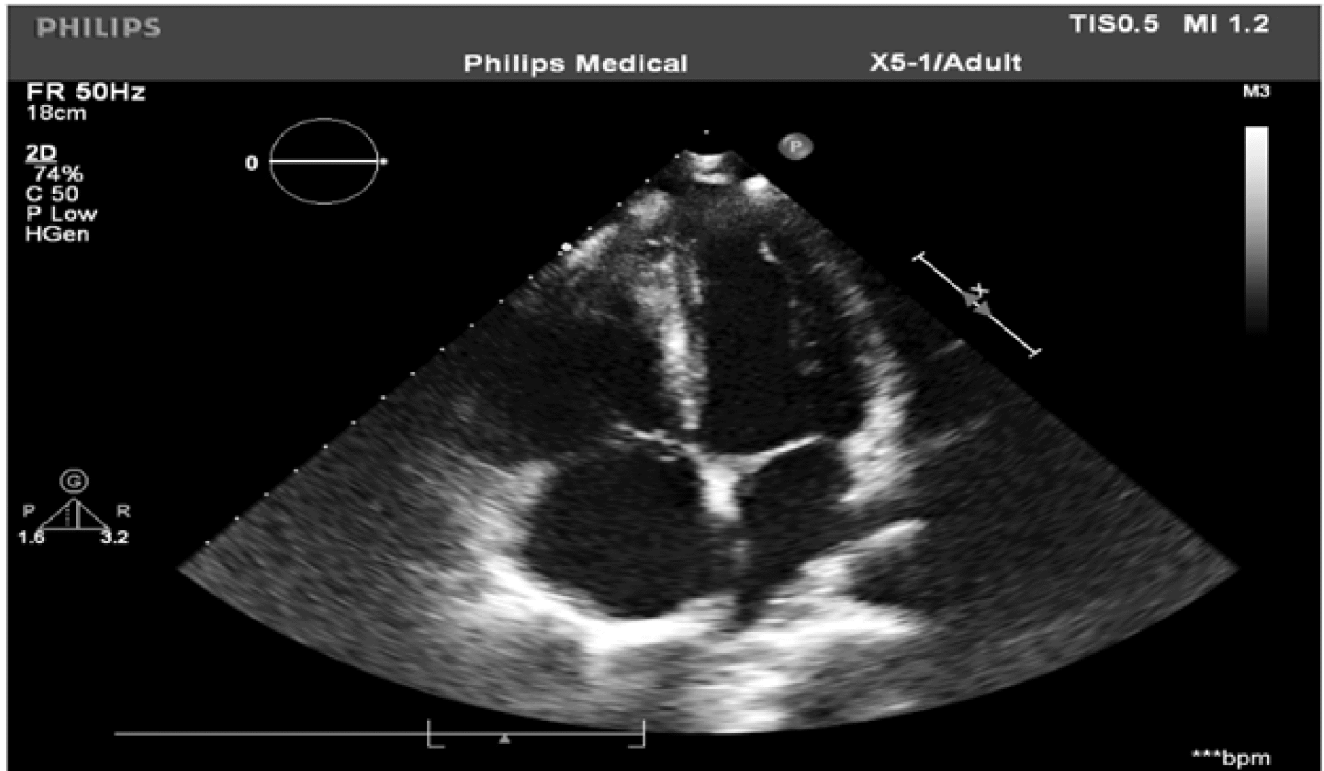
2D echo - apical 4C view of same patient after thrombolysis suggestive of dissolved thrombus in heart.
